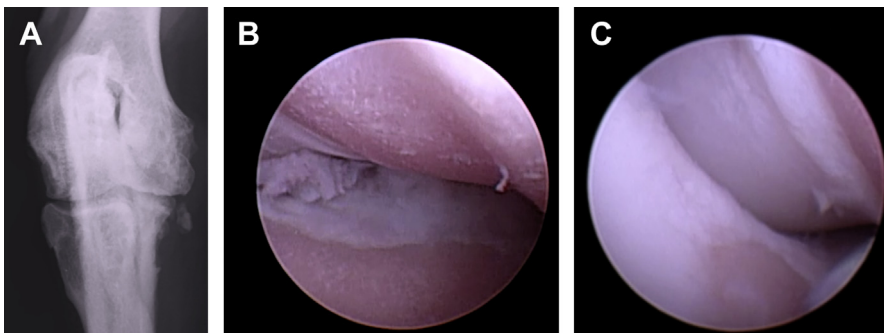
Medial compartment disease of the elbow with severe erosion and subchondral bone exposure of the joint surfaces in the medial aspect of the joint. [A] Radiographic Cr-Cd view showing flattening of the medial condyle. [B] Arthroscopic view of the medial compartment with exposure of the subchondral bone. [C] Arthroscopic view of the neat separation between the lateral compartment with preserved cartilage and the medial compartment without cartilage.
